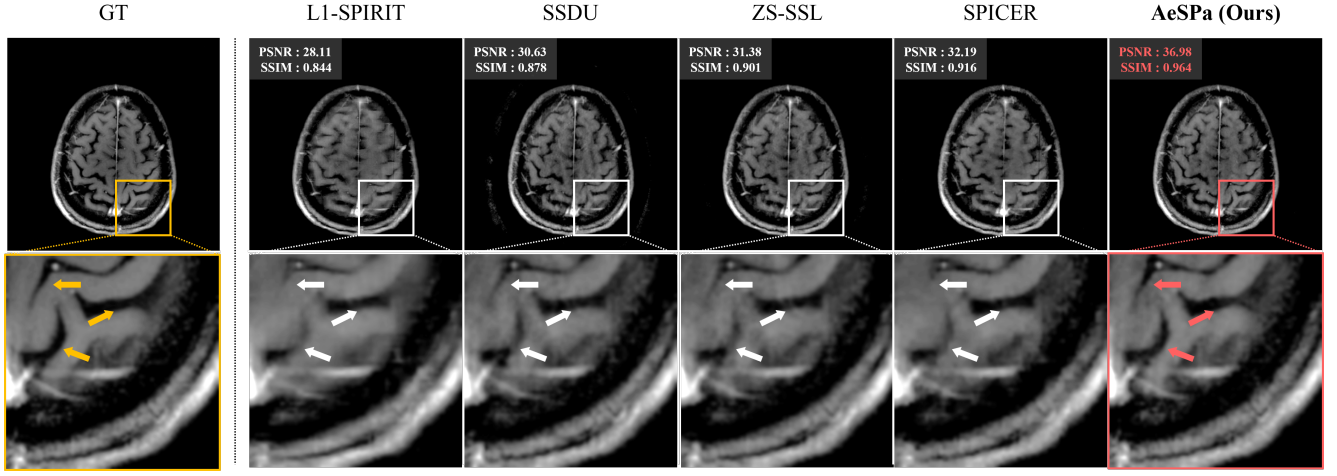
Qualitative results for accelerated MRI reconstruction on the FastMRI brain data. Reconstruction was performed using 1D Uniform sampling with $R = 4$.
